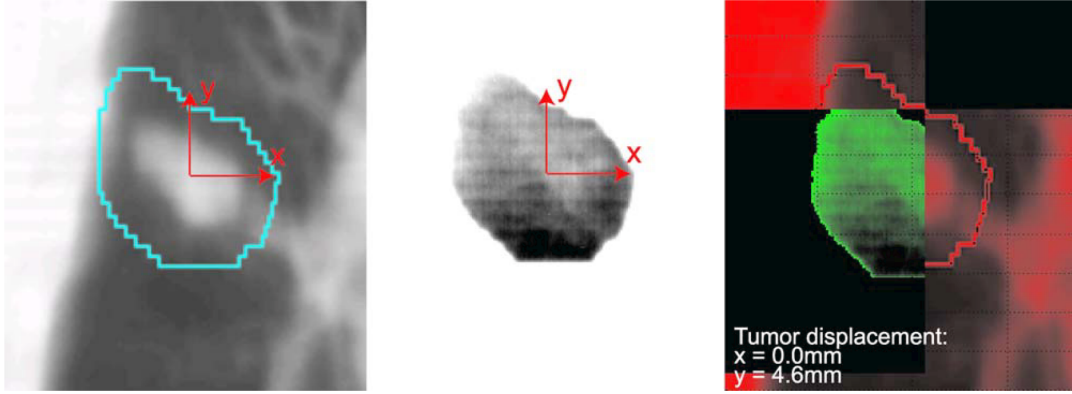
Manual registration of the EPID sequence to the planning CT. On the (*left*) a digitally reconstructed radiograph (DRR) of the patient is shown. In the (*middle*) a sample EPID image of the same treatment field is shown. On the (*right*) the registration tool is shown. The tool was kept quite similar to the tools used in the clinic: it allows translational movement of an image to be registered (green) over the reference image (red). Each beam/fraction sequence of EPID images was registered to the planning CT in this way.
